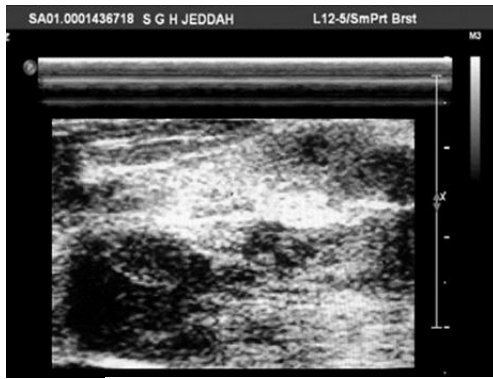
Post Ultrasound guided aspiration of breast abscess with collapsed cavity
